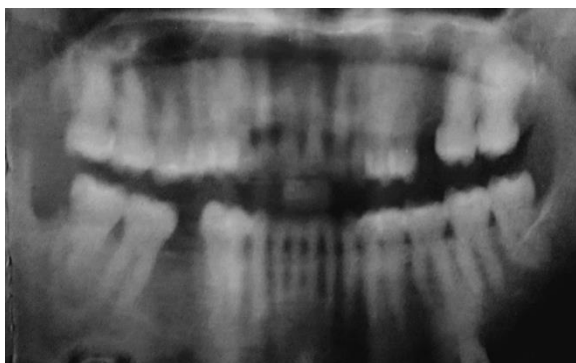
Dental panoramic x-ray of right peripheral odontogenic fibroma
